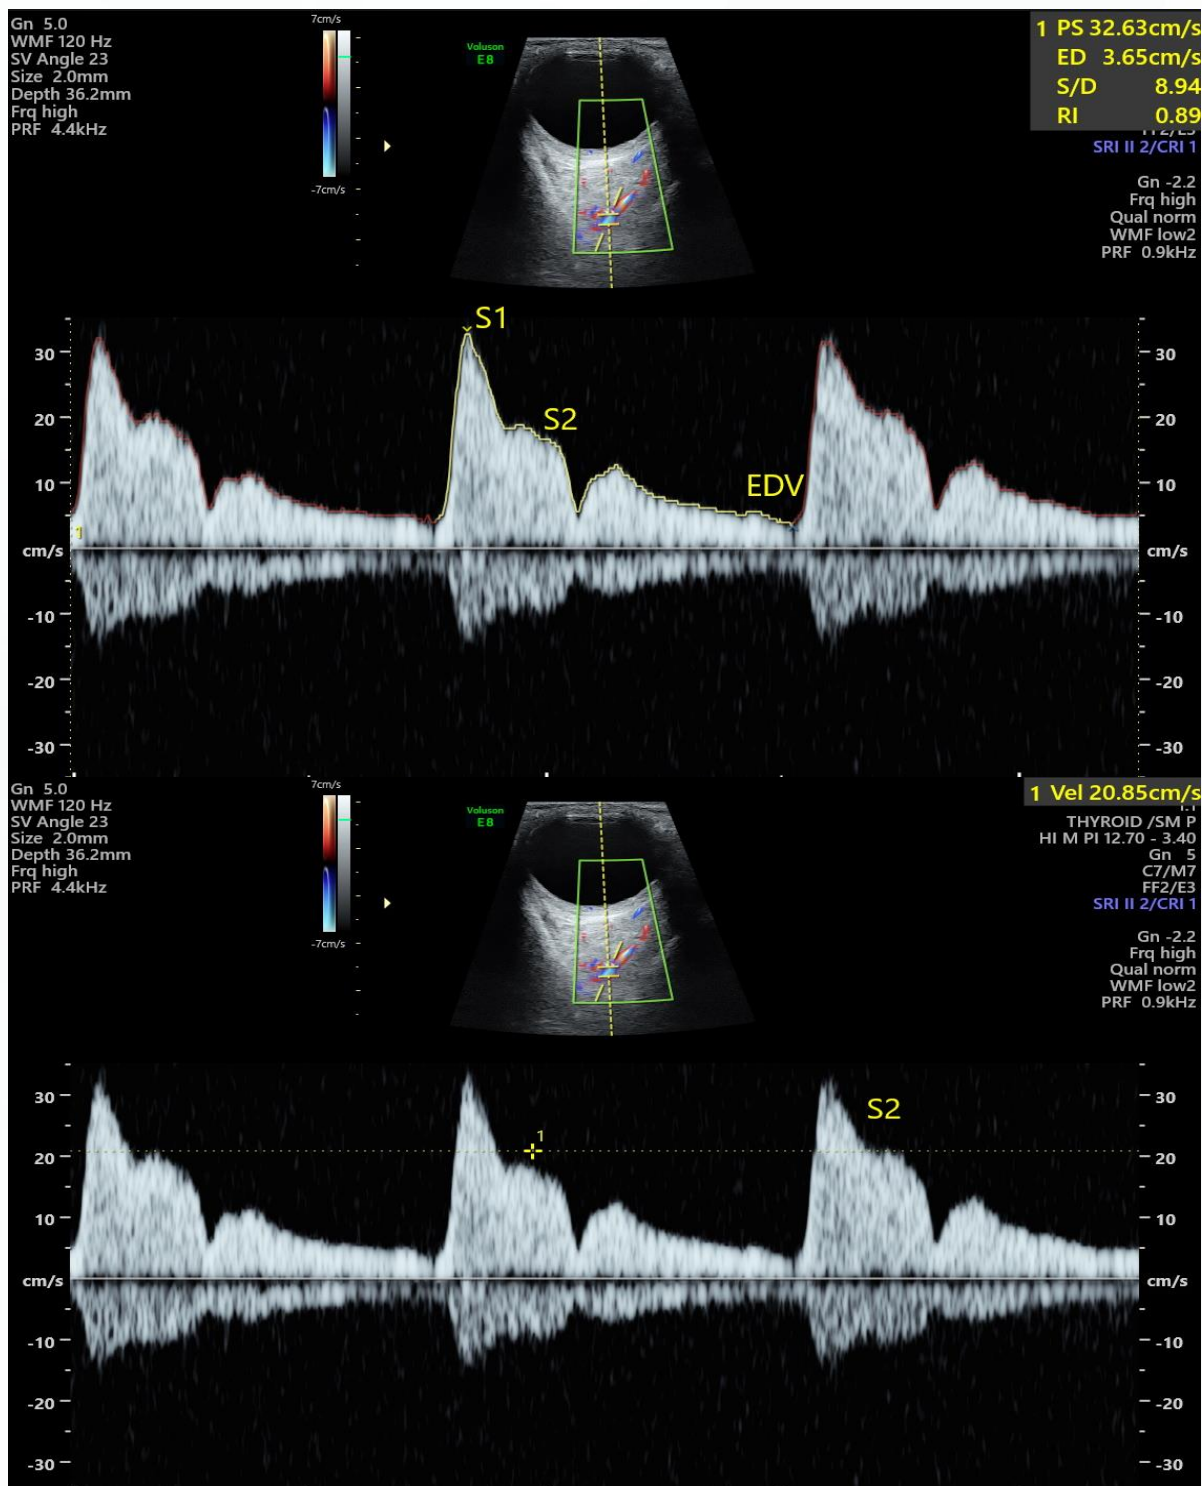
Ultrasound images demonstrating the first and second peaks of systolic velocity and end diastolic velocity. The first systolic velocity is obtained using the auto method whereas the manual method has been used to measure the second peak systolic velocity.
